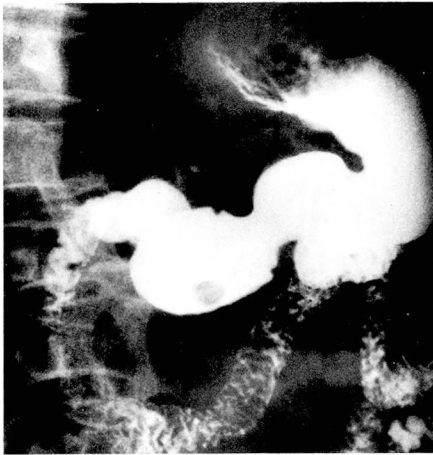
Roentgenogram of stomach showing antral lesion.
